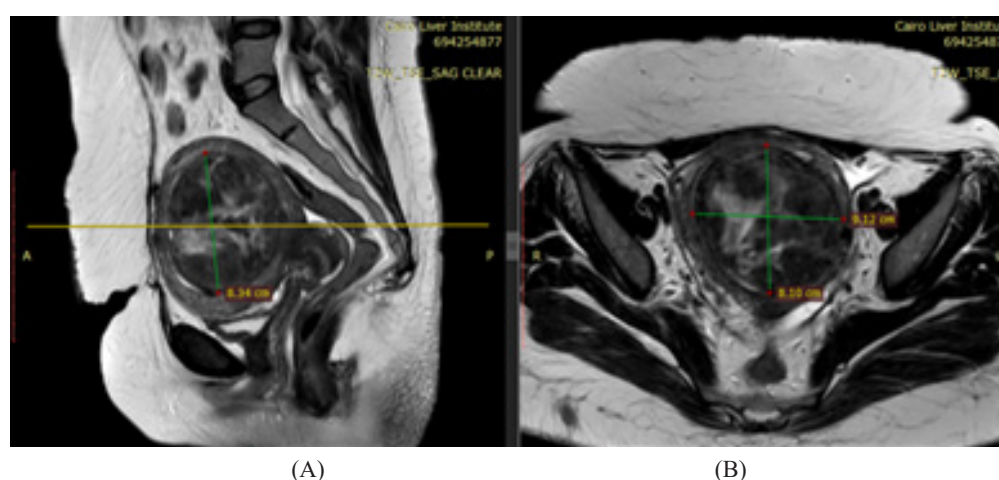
A 42-year-old female presented with heavy menstruation for 5 years since her last birth. She underwent one MR-HIFU session, and now the patient has reported that blood clots have disappeared. (A) Sagittal & (B) Axial T2 MRI images demonstrate a sizable fundal interstitial myoma, showing intermediate/high signal denoting FUNAKI-type III. Total myoma volume before HIFU = 308 cc
